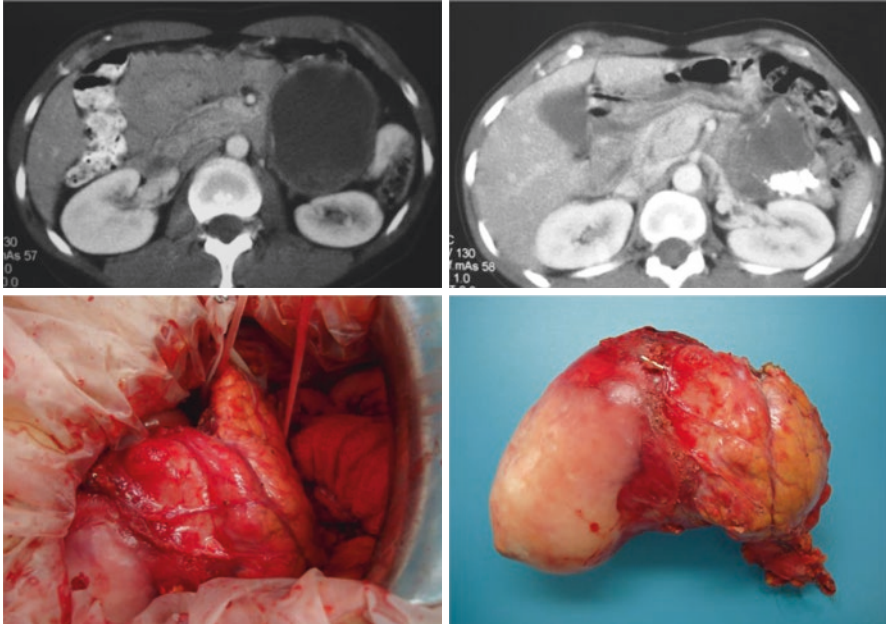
A 45-year-old female patient, complaining of discomfort on the left flank. CT scan shows a solid-cystic lesion with peripheral calcifications located near to the inferior border of the pancreas. During the surgery, a primary lesion of the pancreas projecting into the retroperitoneum was confirmed. Definitive pathological diagnosis of a pancreatic mucinous cystadenoma
